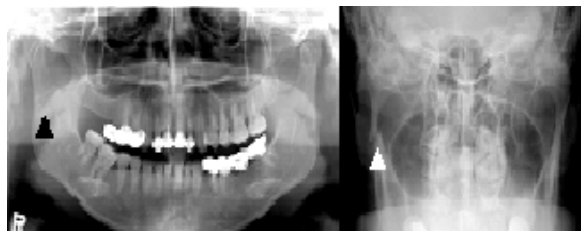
Preoperative panoramic and modified Towne’s radiograph showing right subcondylar fracture (arrow)
